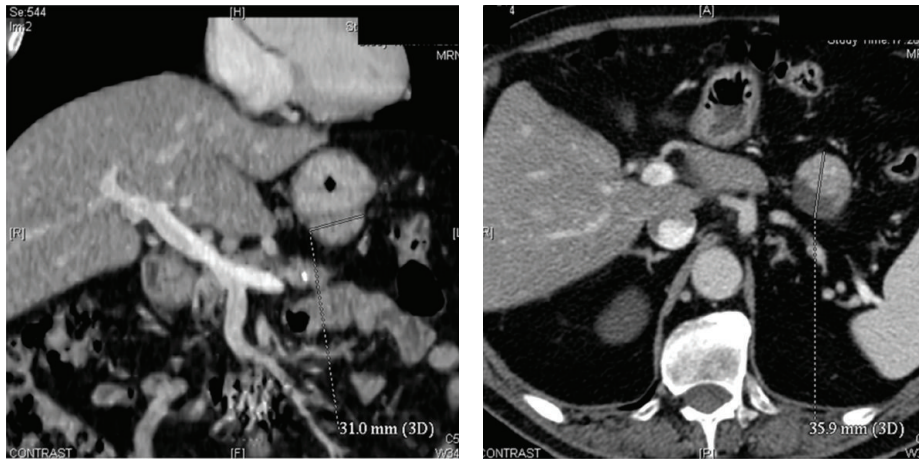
Abdominal CT scan documenting a 3.6 cm GIST of the stomach.
